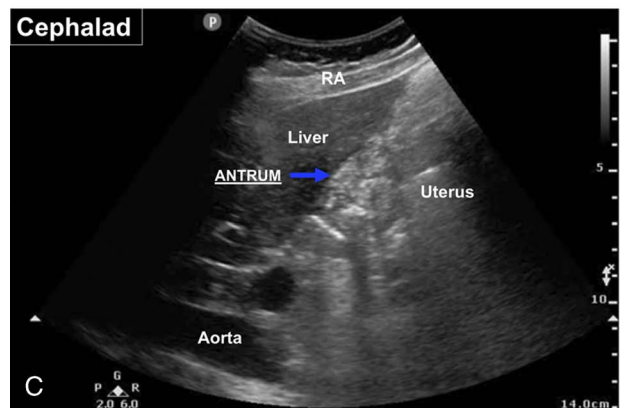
Interpretation of gastric PoCUS findings. Adapted and modified with permission from gastricultrasound.org.
